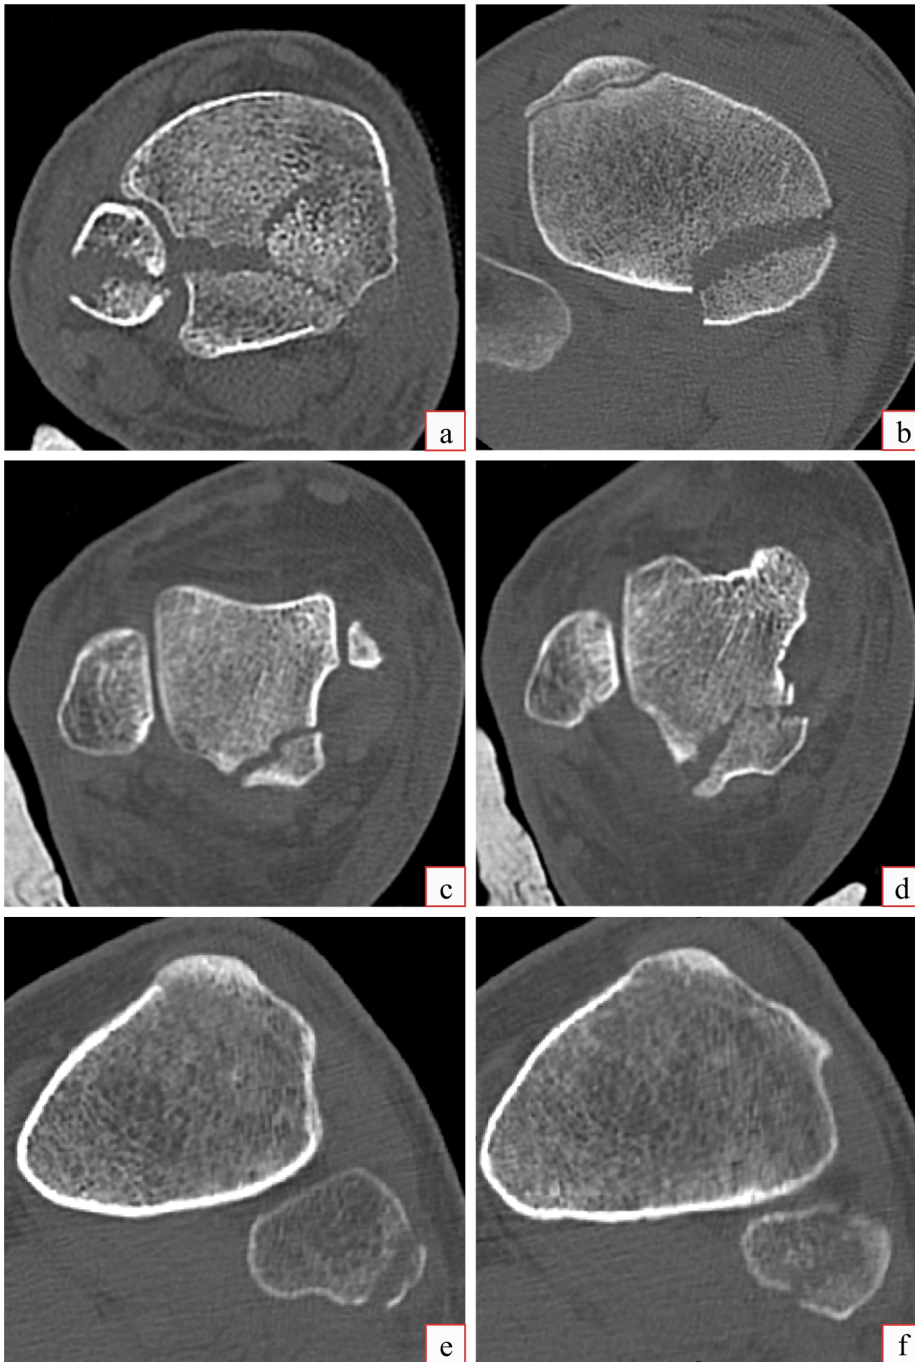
CT images that represent different simple fractures. (a) contains, among others, a greenstick fracture, since the bone is not completely broken. The remaining images contain simple fractures with (b) and without (c, d, e, f) bone displacement.
